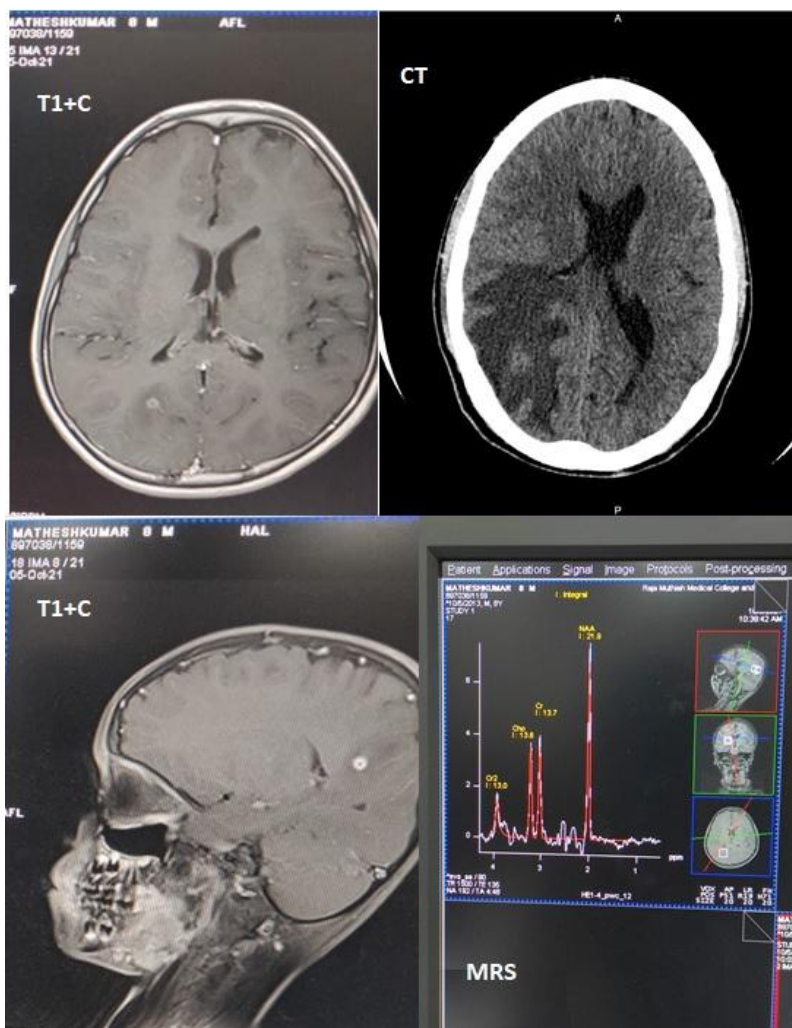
shows the CT brain image taken a year back and the recent MRI with MRS images depicting Neurocysticercosis in the right parietal lobe
